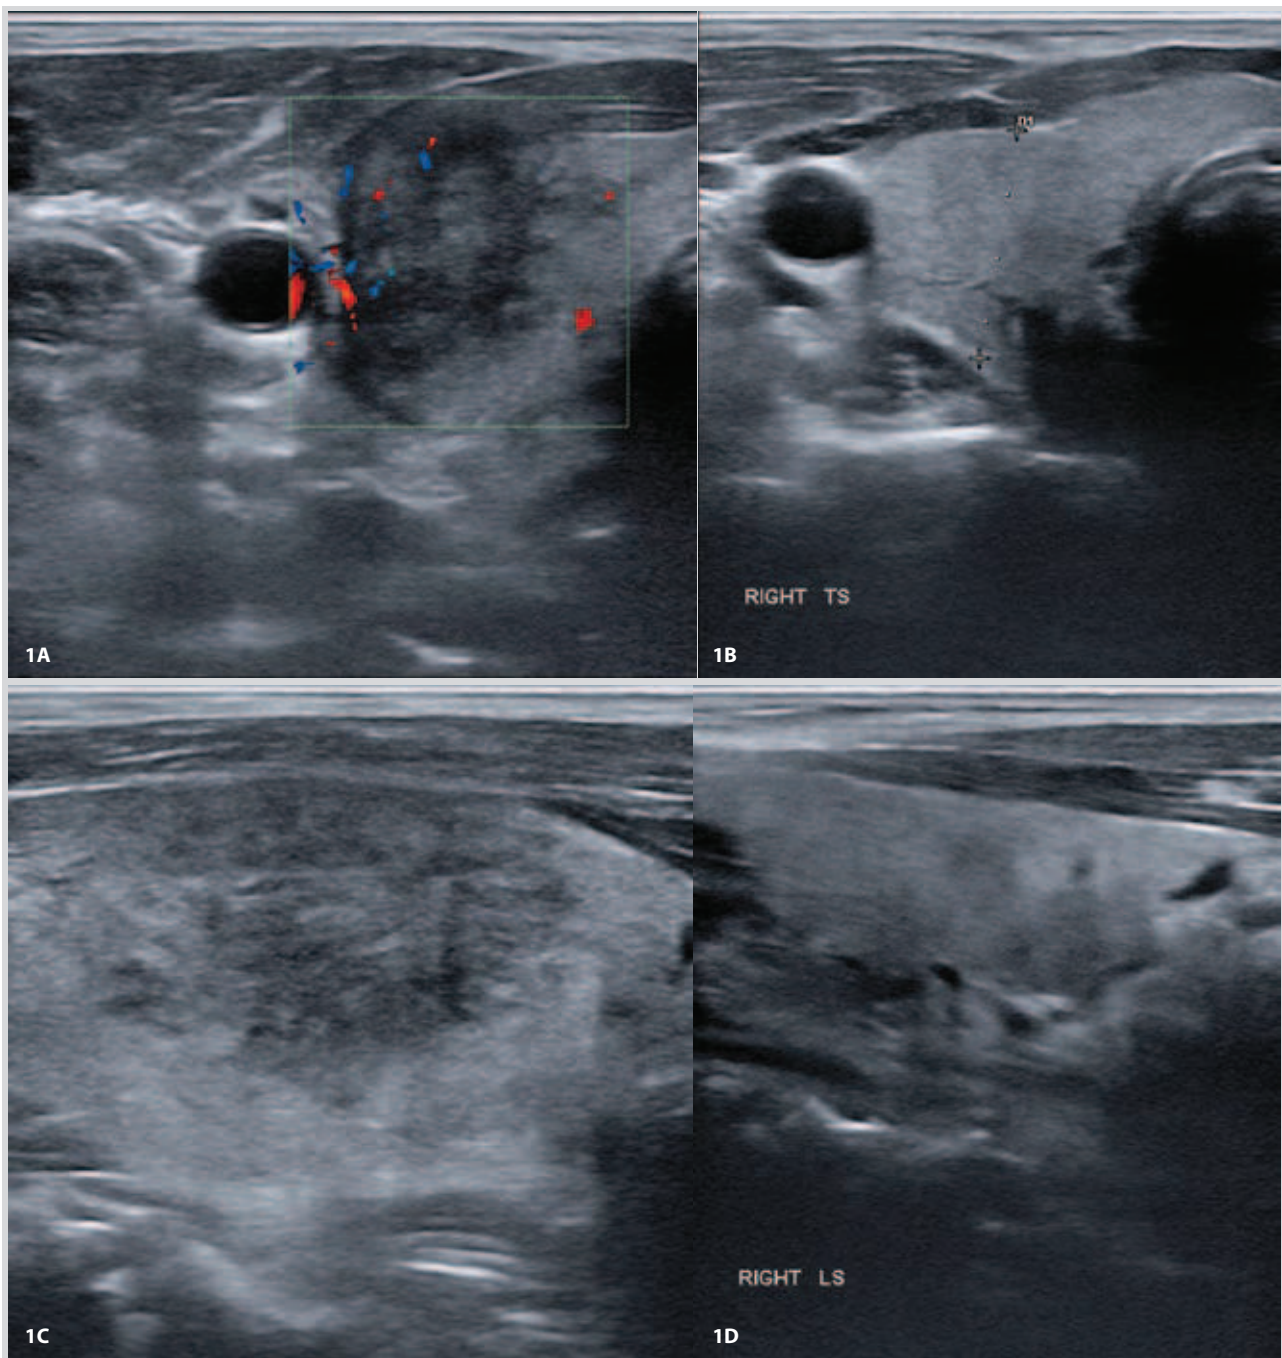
Figures 1A and 1C represent the transverse and longitudinal section sonographic images, respectively, of the right lobe of the thyroid gland, obtained during the original presentation of the patient. The thyroid gland was enlarged with an antero-posterior diameter at 25.2 mm and 20.5 mm on the right and left lobe (normal <20 mm), respectively. There was significant heterogeneity and non-specific hypoechoogenicity affecting about two-thirds of the gland. No nodules were visible. Vascularity was overall reduced. The rest of neck had a few bilateral level 3 lymph nodes with normal hilum and vascularity (reactive lymph nodes). Figures 1B and 1D represent the transverse and longitudinal section images, respectively, of the right lobe, obtained six months after the original presentation of the patient and his treatment with glucocorticoids. They show normal homogeneous appearances of the thyroid gland and with normal vascularity; the AP diameters had also normalized at 17.8 and 13.6 mm on the right and left lobe, respectively. These changes were indicative of resolution of the inflammation.
